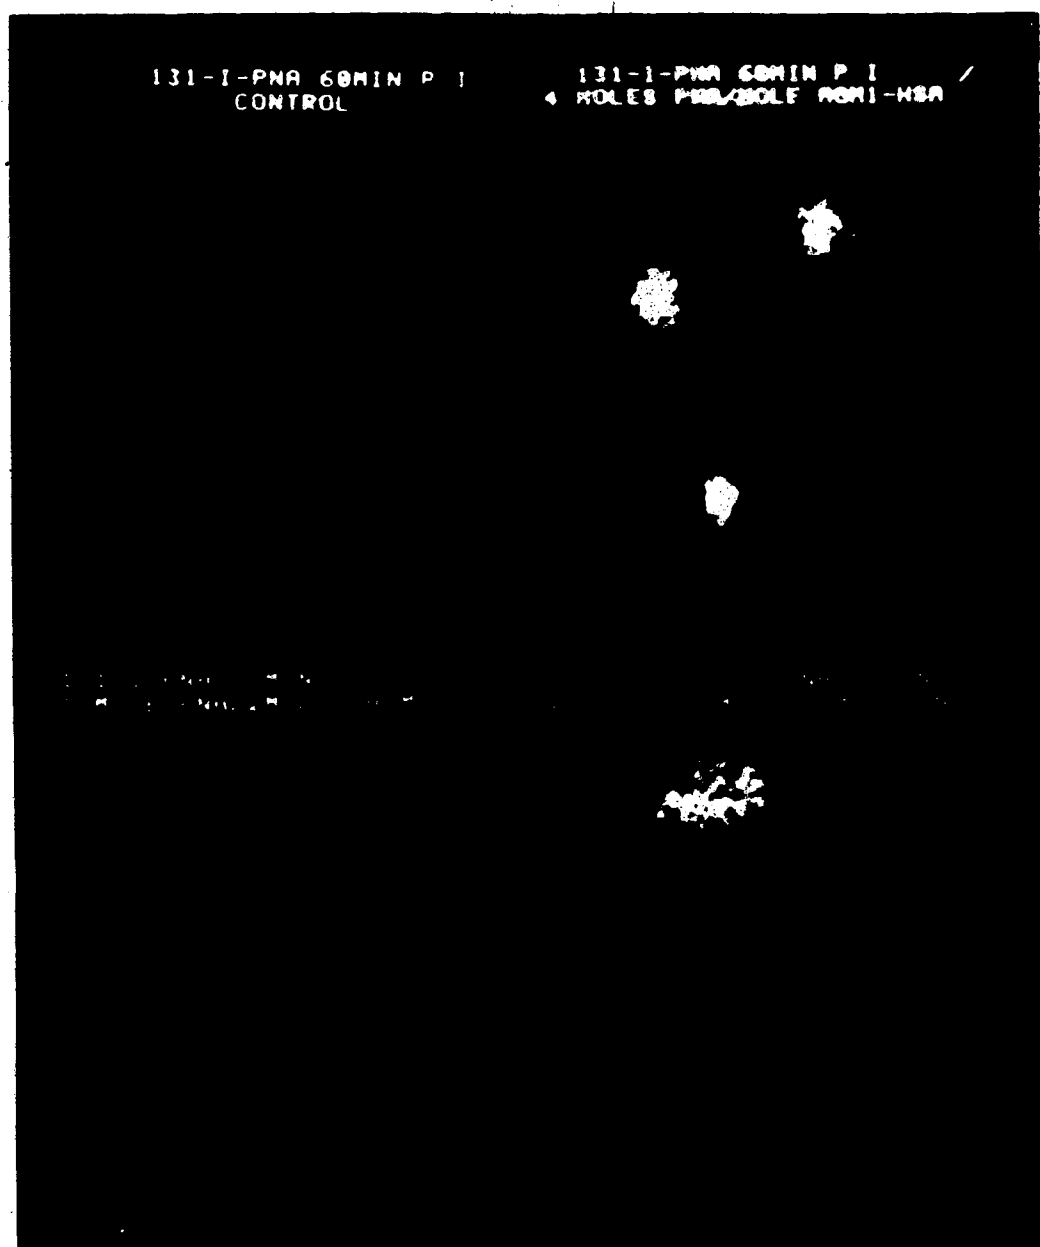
Static scintigrams of various molar ratios of ^{131}I -PNA: α -GM₁-HSA at 1 h post injection.
